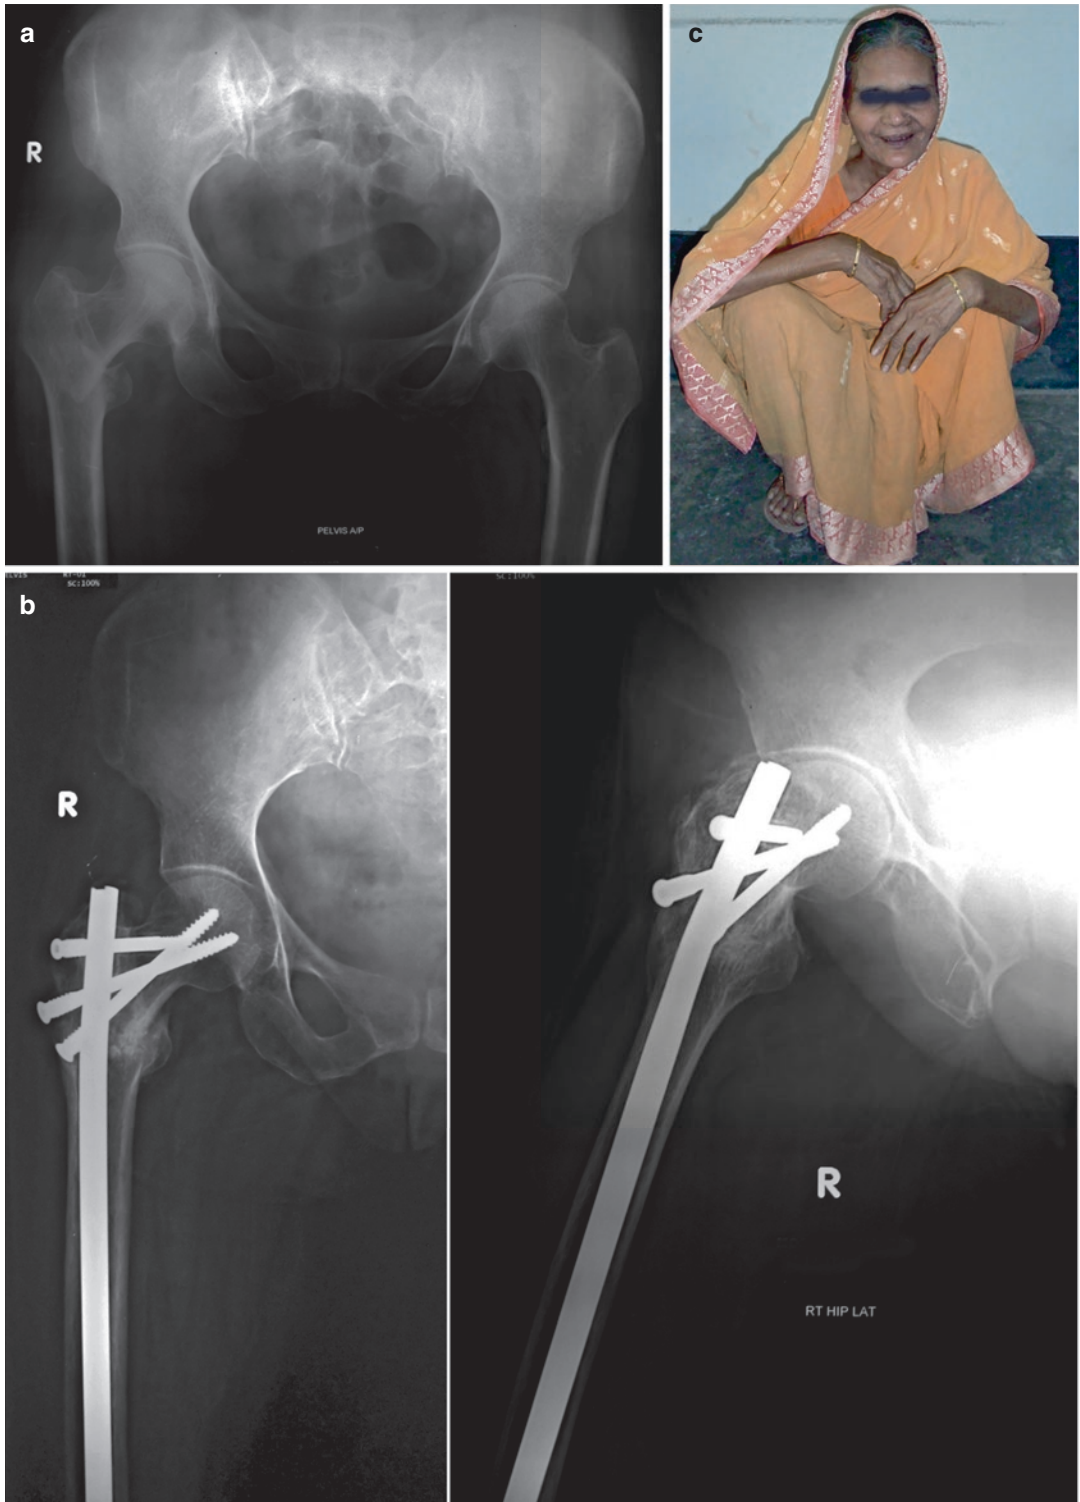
(a) X-ray of a two-part intertrochanteric fracture in osteoporotic bone. (b) ORIF with the antegrade SIGN nail, with two free screws traversing the fracture
